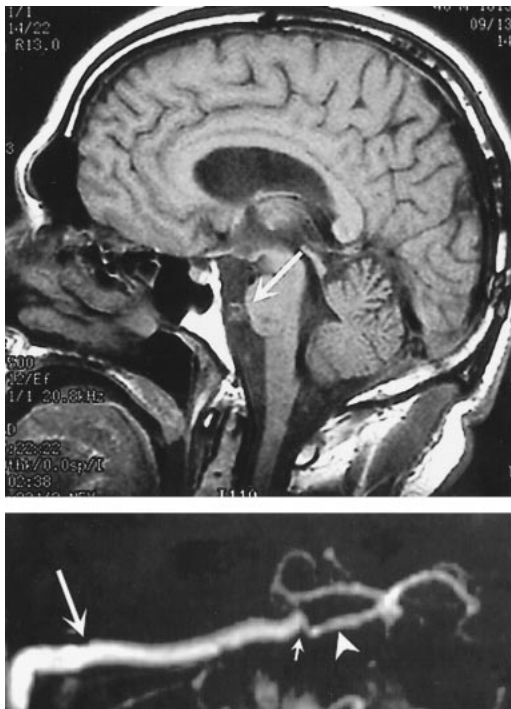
Postoperative sagittal view MR image of the brain (top), obtained 14 months after the second EC-IC bypass procedure was performed, reveals near-complete resolution of the aneurysm (arrow). MR angiogram (bottom) shows filling of the superior cerebellar artery (arrowhead) through an anastomosis (small arrow) with a patent saphenous vein graft (large arrow). No blood flow was detected in the aneurysm.
